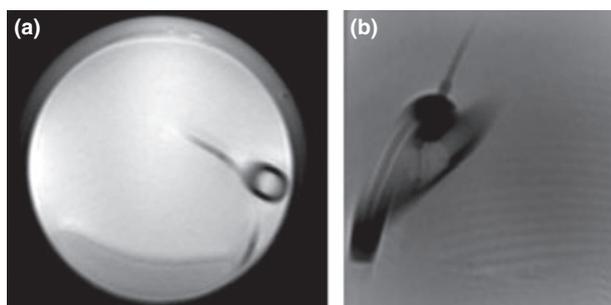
Axial and sagittal magnetic resonance images of the Classic LMA with the pilot balloon cut off; the artefacts have disappeared. (compare with images in Figs 2a and 3a).
